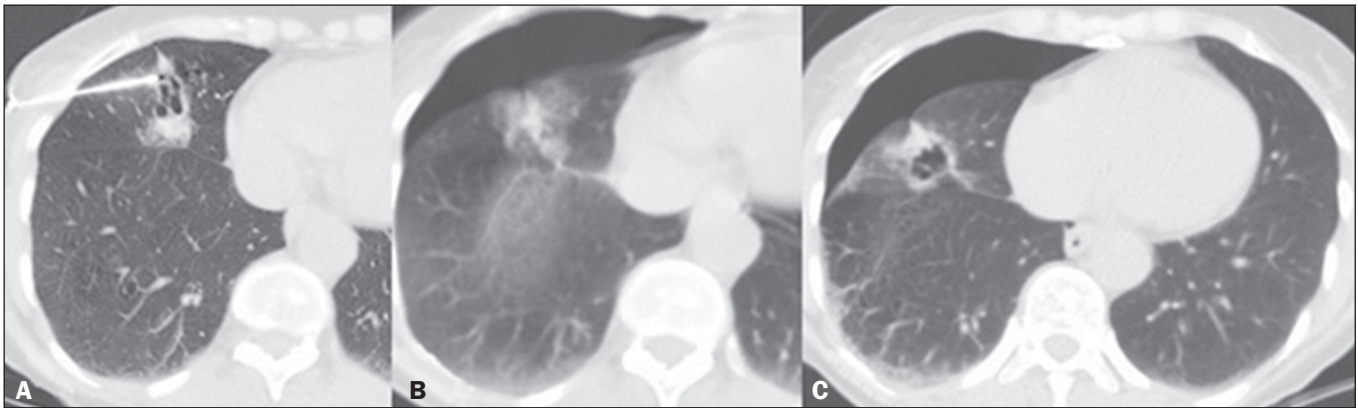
A: Cavitary pulmonary nodule with irregular margins, measuring 8 mm, with needle insertion into the lung parenchyma. B: Small pneumothorax after collection on immediate follow-up CT. C: Follow-up CT at three hours after the procedure, showing stabilization of the pneumothorax.
